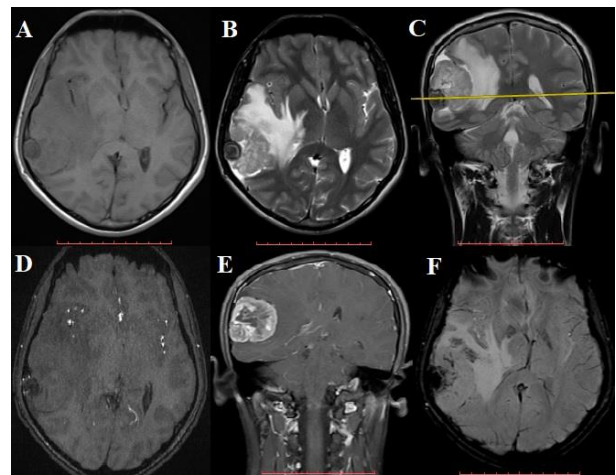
An 18-year-old boy presented to our outpatient clinic with a one-month history of headaches. His neurological examination was intact except for increases in DTRs. A contrast-enhanced MRI revealed a well-capsulated heterogeneously enhancing tumor measuring 4.9x4.5x4.2 cm. The mass was located in the right temporoparietal region and surrounded by diffuse edema. The lesion made a 7-8 mm shift to the left side and extending into the underlying brain
